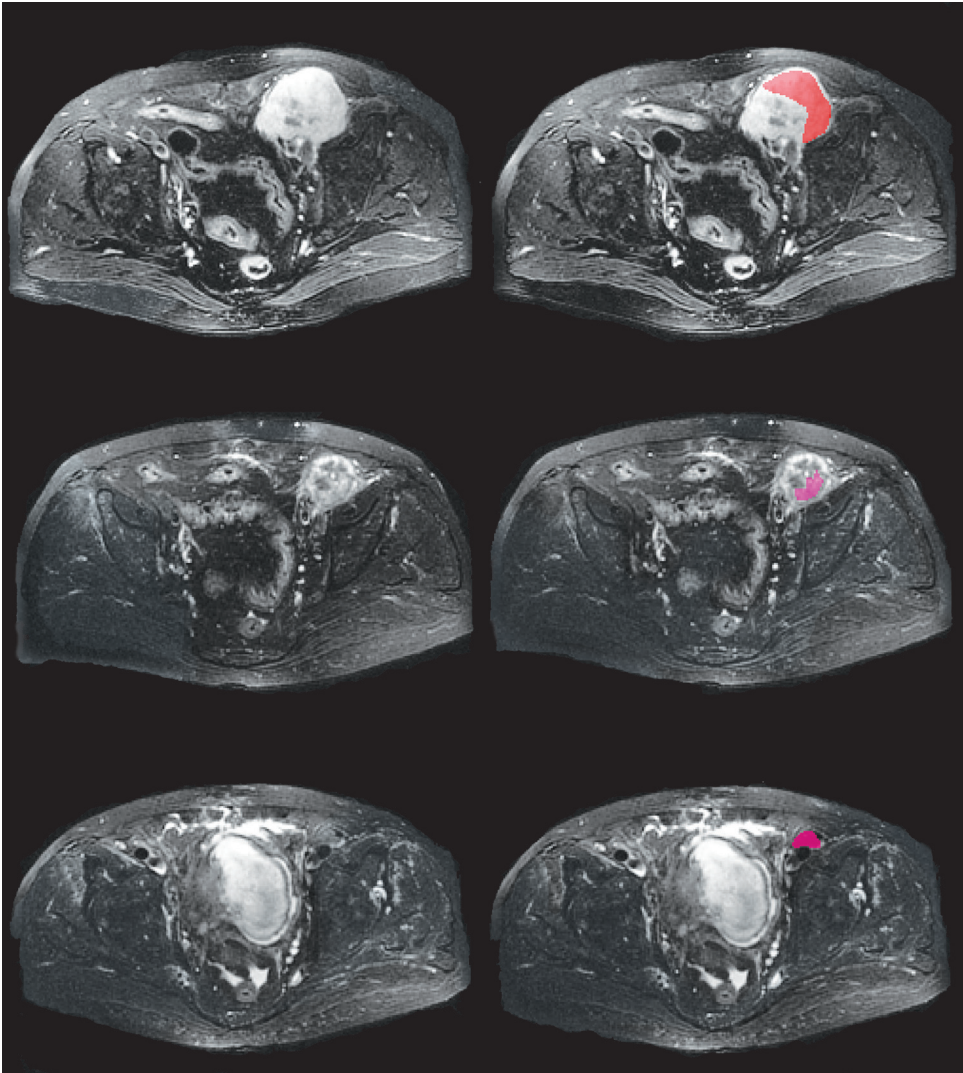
Axial T2-weighted FSE fat saturation image slices of a typical subject (left), and ROIs drawn on the lymphoma mass (right). Images in the first row are from the diagnostic phase (examination 1), images in the second row are from examination 2, and images in the last row are from examination 3.
